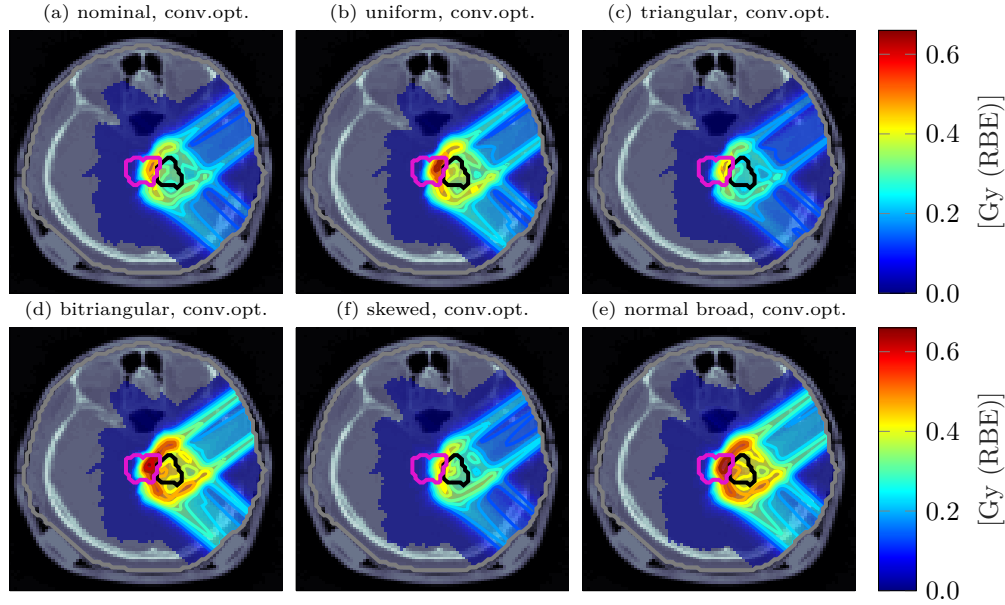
Transversal CT next to the iso-center of the intra-cranial case superimposed by transparent dose colorwash representing the standard deviation assuming different PDFs. Solid lines indicate iso-dose lines whereas the solid black contour denotes the CTV and the pink contour the brainstem. Pencil beam intensities are based on conventional optimization on the PTV (not shown). The two proton beam direction with gantry angles 50° and 135° were utilized.
